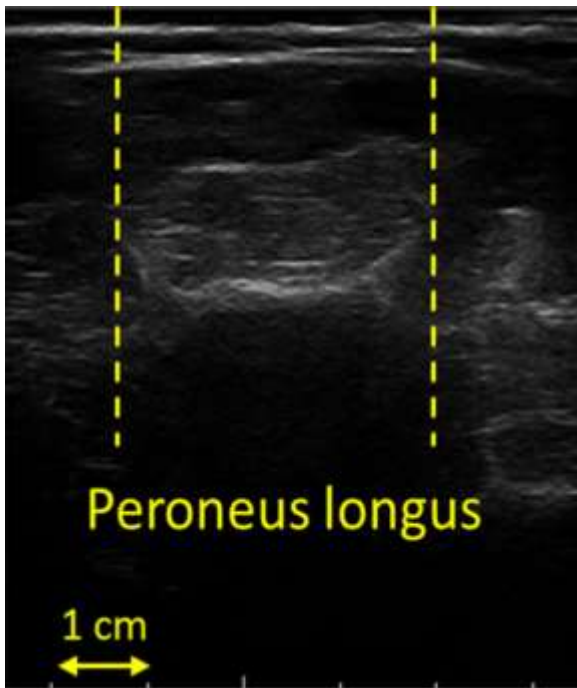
Ultrasound image of the peroneus longus in the transverse plane, dashed lines indicate the borders of the PL muscle
